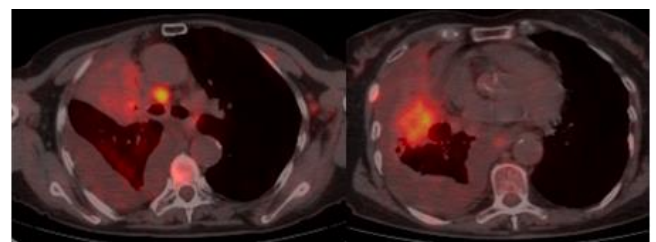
PET-CT Imaging of Case 1: Increased FDG uptake in the right lower paratracheal lymph node, 30x20mm in the central part of the upper lobe and 55x40mm in the distal middle lobe (SUVmax:5.1- 6.0)
